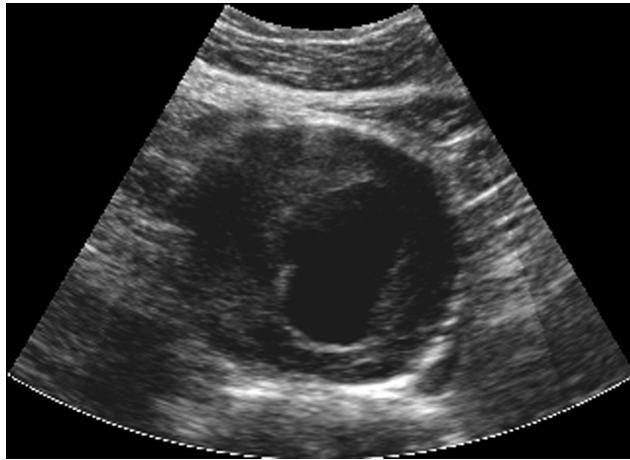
Ultrasound image of abdominal aortic aneurysm. Note the presence of a large thrombus inside the aneurysm sac.
